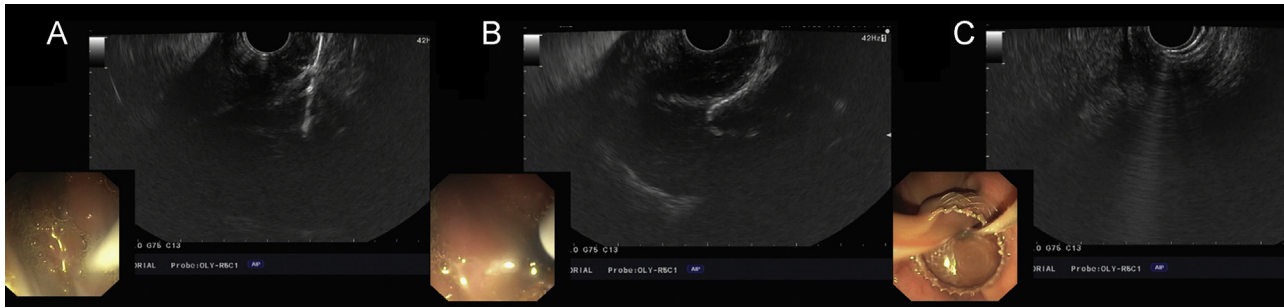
(A) Access with the cautery tip of the Hot AXIOS catheter under endosonographic guidance. (B) Deployment of the distal flange under EUS. The distal flange presents a characteristic echogenic mark resembling a mushroom. (C) Deployment of the proximal flange under endoscopic view. Pus flows through the stent.
